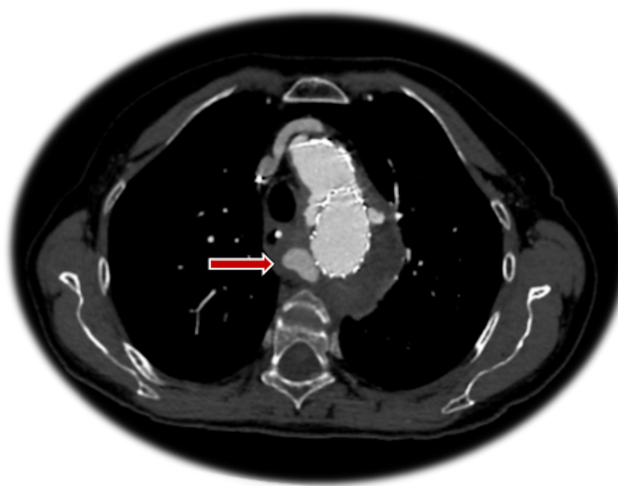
The CTA image shows an enlarged infective pseudoaneurysm
